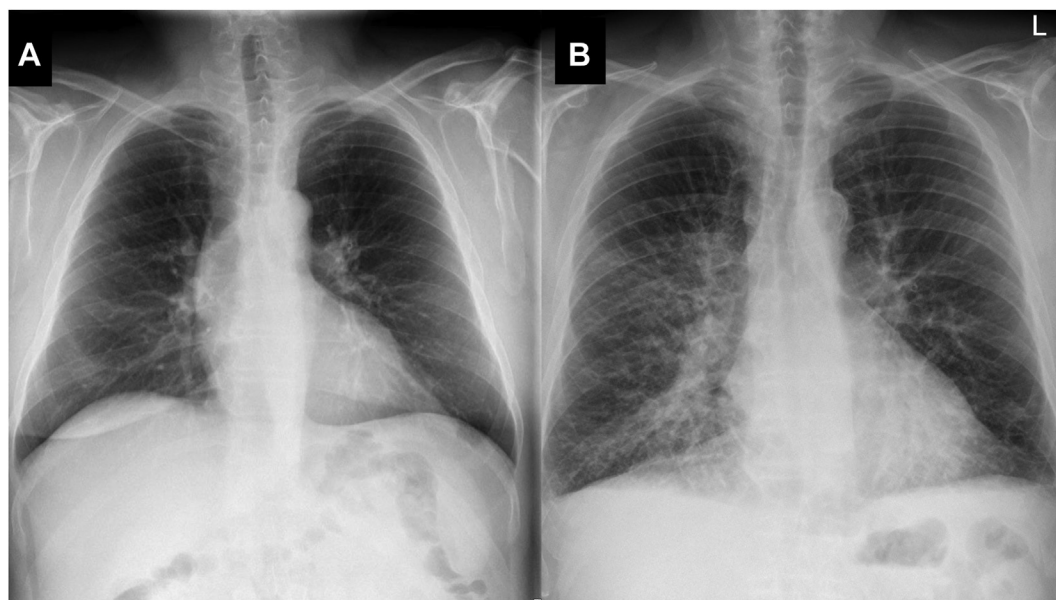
Two examples of a low and a high radiograph congestion score (RxCS; only posterior-anterior radiographs are shown). (A) A 51-year-old man. RxCS = 0; mean pulmonary artery pressure (mPAP) = 26 mm Hg; mean pulmonary artery wedge pressure (mPAWP) = 20 mm Hg; pulmonary vascular resistance (PVR) = 1.2 Wood units. (B) 79-year-old man. RxCS = 6; mPAP = 37 mm Hg; mPAWP = 18 mm Hg; PVR = 4.2 Wood units.
